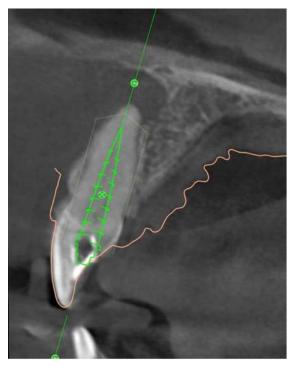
Pre-operative photograph and radiographic examination. (a) Tooth 11
